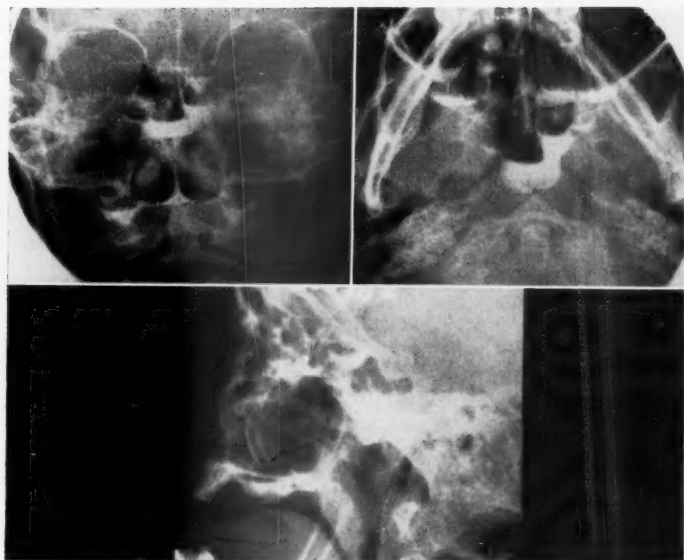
X-rays showing displacement of radiopaque oil into all sinuses except the frontals.
